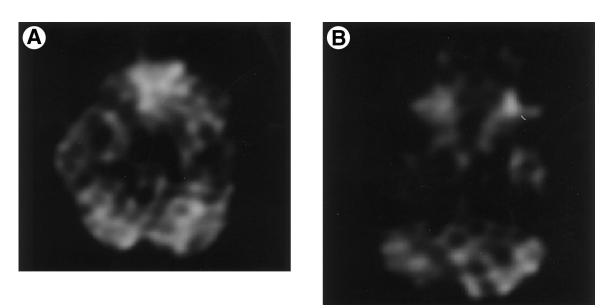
FDG PET scan of a patient with a head injury that resulted in hypometabolism in the left temporal lobe (A) with associated crossed cerebellar diaschisis demonstrated by hypometabolism in the right cerebellum (B).
